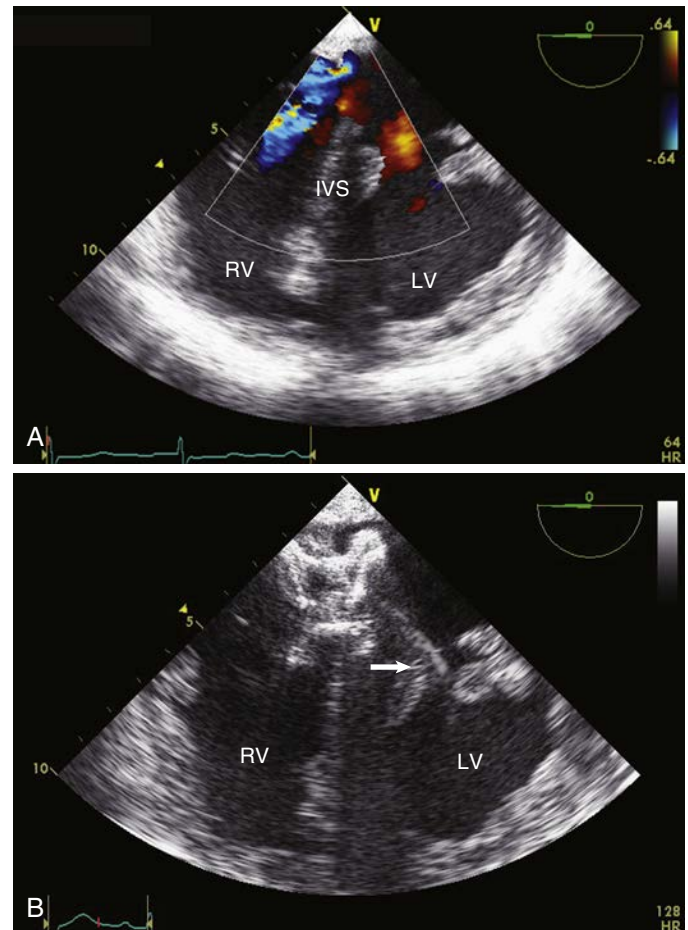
Ventricular septal defects (VSDs). Three days after an acute inferior myocardial infarction, the patient exhibited clinical deterioration, and a new systolic murmur was heard. (A) Transesophageal echocardiography (TEE) transgastric view at 0 degrees with color Doppler showed a shunt from the left to the right ventricle (LV, RV), typical of a VSD. (B) TEE guidance (arrow, delivering catheter) for percutaneous closure of the VSD, achieved using an Amplatzer device. IVS, Interventricular septum.
